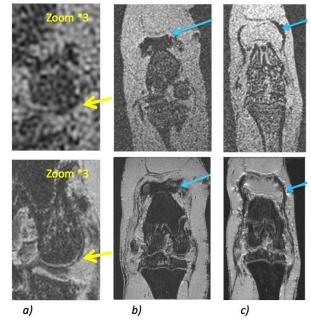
Intra-articular SPION (n=12, 12ug on day 2 of AIA) MRI is 2 hrs (a, zoom x3, and b) and 5 days (c) after SPION at 3T (upper) and 14T (lower). Yellow arrows indicate improved visualization of cartilage structure at 14T. SPION is indicated by blue arrows and shows the distribution change with time at both fields.
